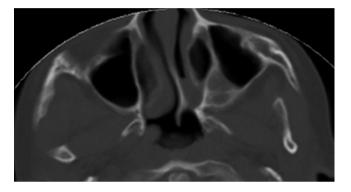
Computed tomography image (axial view) of a child with unilateral (*left*) choanal atresia. The image demonstrates a combined bony and membranous atretic plate, deviated vomer, and medialized left medial pterygoid plate
